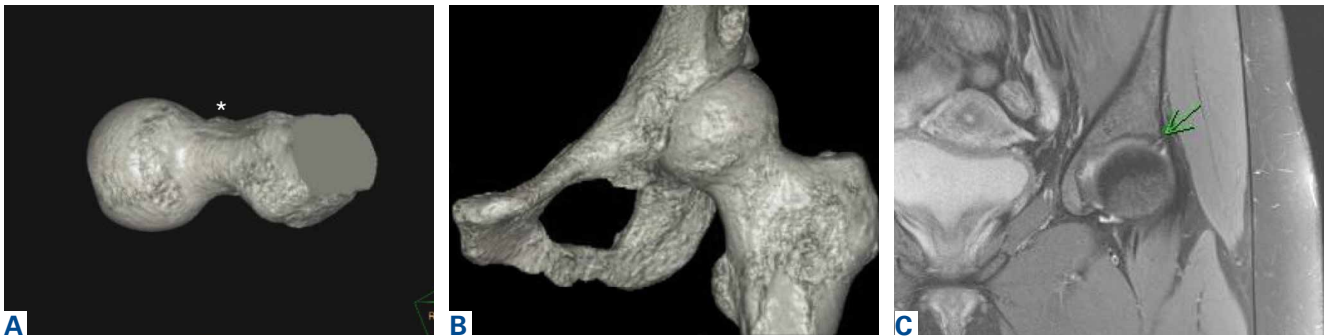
Volumetric interpolated breath-hold examination (VIBE) 3.0 Tesla magnetic resonance imaging (MRI) sequence with 3-dimensional rendering. (A) Femoral isolation. Asterisk indicates cam lesion on femoral neck. (B) Acetabular rim. (C) Noncontrast MRI with labral tear. Green arrow shows labral tear.
